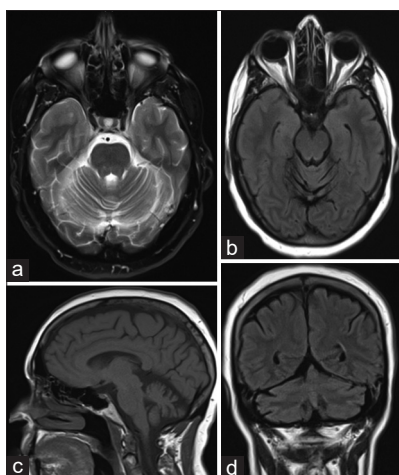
Brain MRI shows cerebellar atrophy on T2 axial [a], axial fluid-attenuated inversion recovery (FLAIR) [b], sagittal FLAIR [c], and coronal FLAIR [d]
